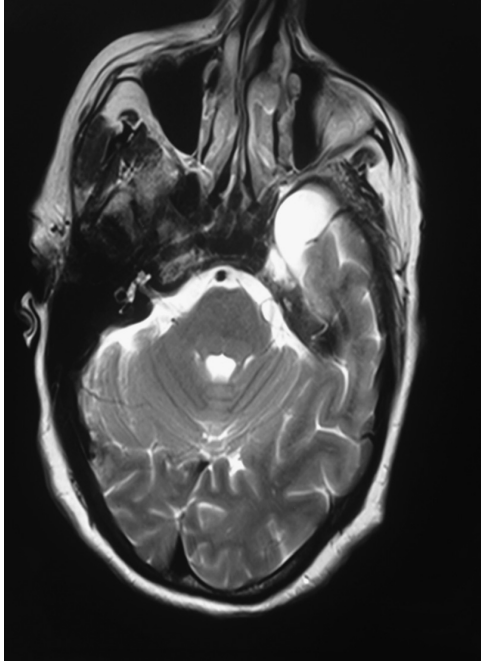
Magnetic resonance imaging scan showing the arachnoid cyst in the left anterior temporal region.
